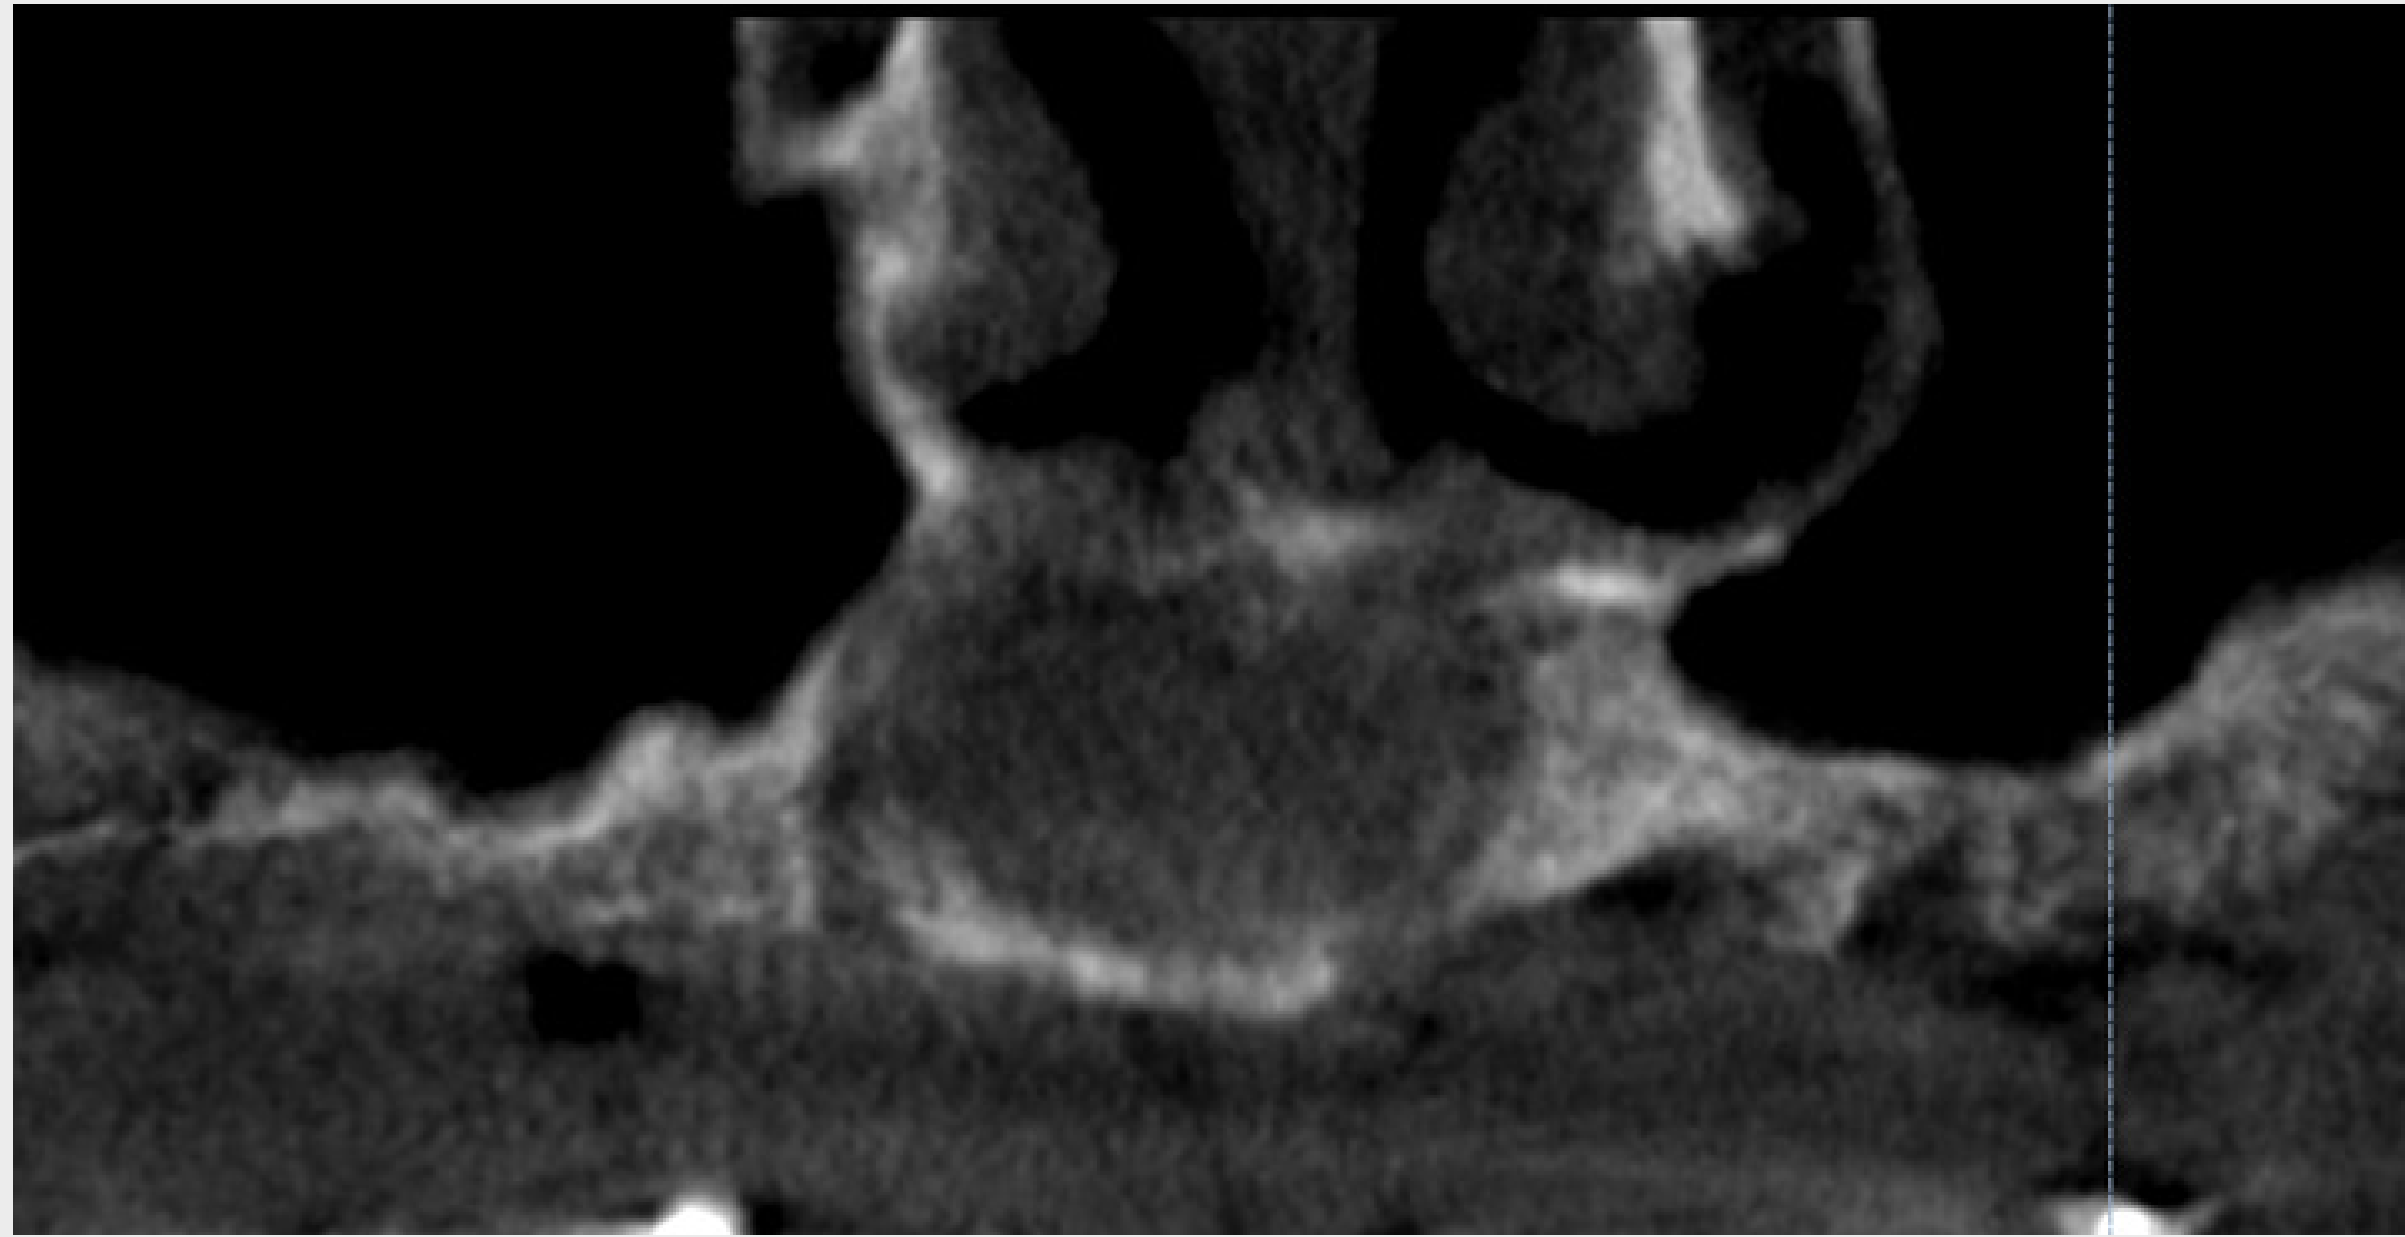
CBCT panoramic cut after teeth extraction and emptying of the cystic area.
